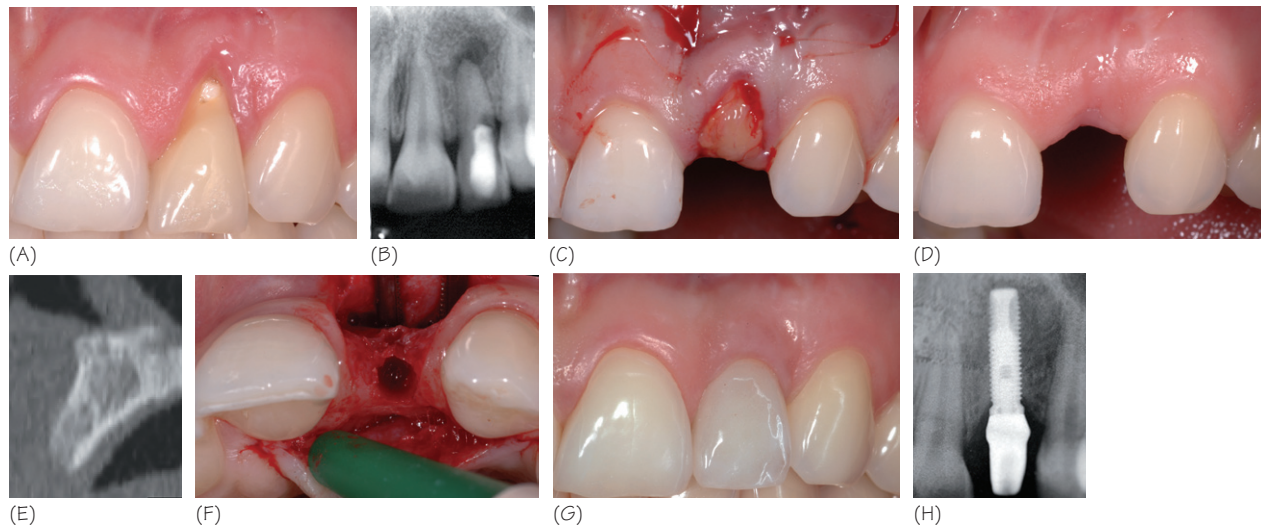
The Bio-Col socket preservation technique. (A) Soft tissue recession on 22 (hopeless tooth). (B) Intraoral radiography showing an endodontic lesion and root perforation. (C) Stabilization of a connective tissue graft with mattress sutures. (D) Three months healing, before implant surgery. (E) Three months CT scan showing bone preservation. (F) Implant bed preparation. (G) Five-year clinical result. (H) Intraoral radiography (5 years).
